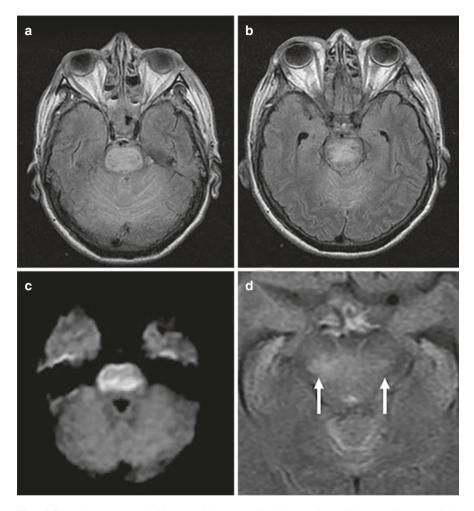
Brainstem encephalitis caused by West Nile virus. (a, b) Axial FLAIR images of the brainstem, showing diffuse central spread at the midbrain-pons region. (c) Axial DWI, at the same level, demonstrating avid restricted diffusion. (d) Axial FLAIR image showing bilateral involvement of the substantia nigra, more pronounced on the right (arrows)
